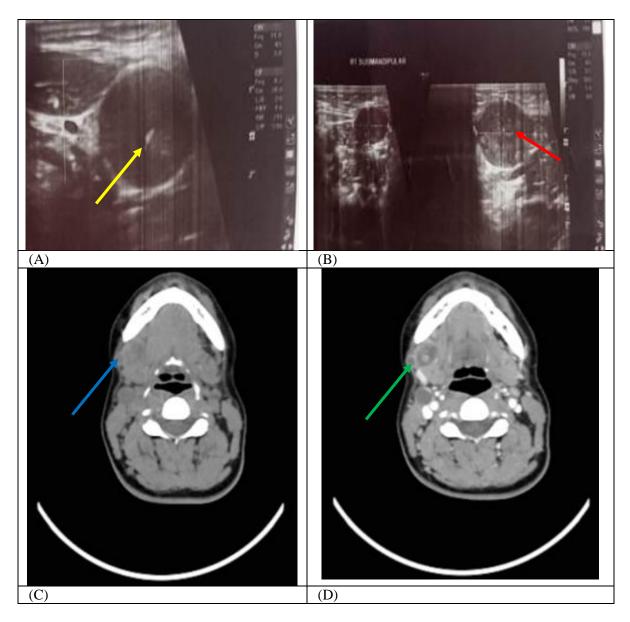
48 years female patient complained of painless swelling in right buccal region 1 year ago, neck ultrasound done showing multiple well defined hypoechoic pathologically enlarged lymph nodes all are losing the fatty hilum and rounded seen upper deep cervical, intraparotid (A yellow arrow) and submandibular region(B red arrow), CT neck with IV contrast showing a rather well-defined multiloculated partially cystic partially solid dense marginally enhanced soft tissue mass lesion seen within lateral aspect of right buccal mucosa causing localized skin contour bulge and seen separable from the tongue.(B without contrast blue arrow), (D with contrast green arrow), diagnosed as right buccal minor salivary gland malignant lesion and final diagnosis was buccal minor salivary gland squamous cell carcinoma.
